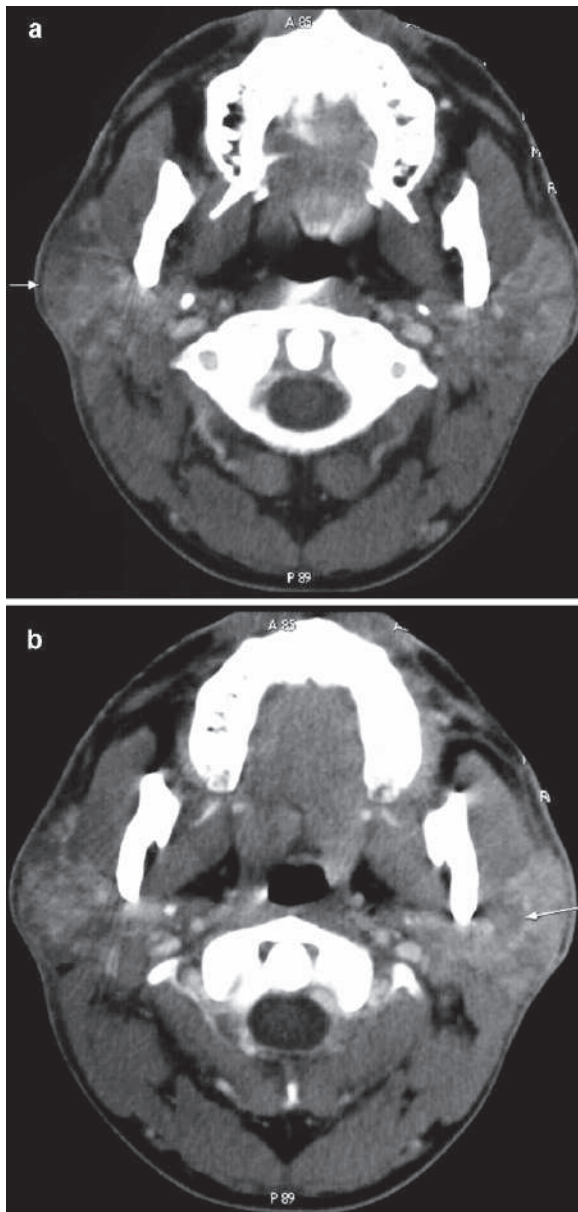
Sequential postcontrast head CT images (a) and (b) of a patient with Sjögren syndrome (SS) show bilateral parotid gland bulging and enlargement (arrows)
